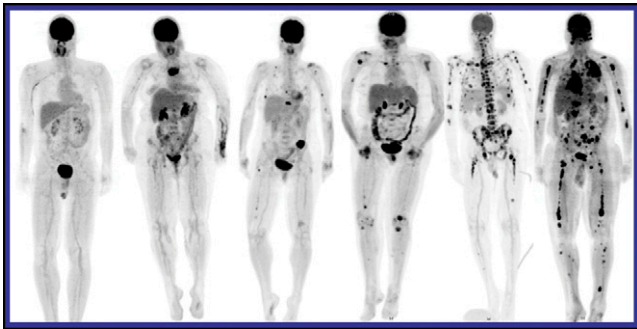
The severity of lesions at baseline ^{18}F -FDG PET in multiple myeloma was correlated with outcome. From left to right, these patients were found to have no, >5 , >10 , >20 , >50 and >70 focal lesions, respectively.
